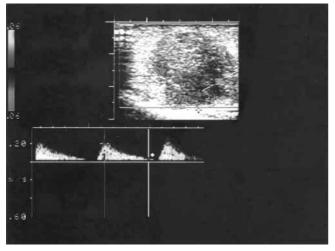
Colour Doppler sonogram analysis demonstrates increased resistive index arterial flow within hypoechoic testicular tumor
